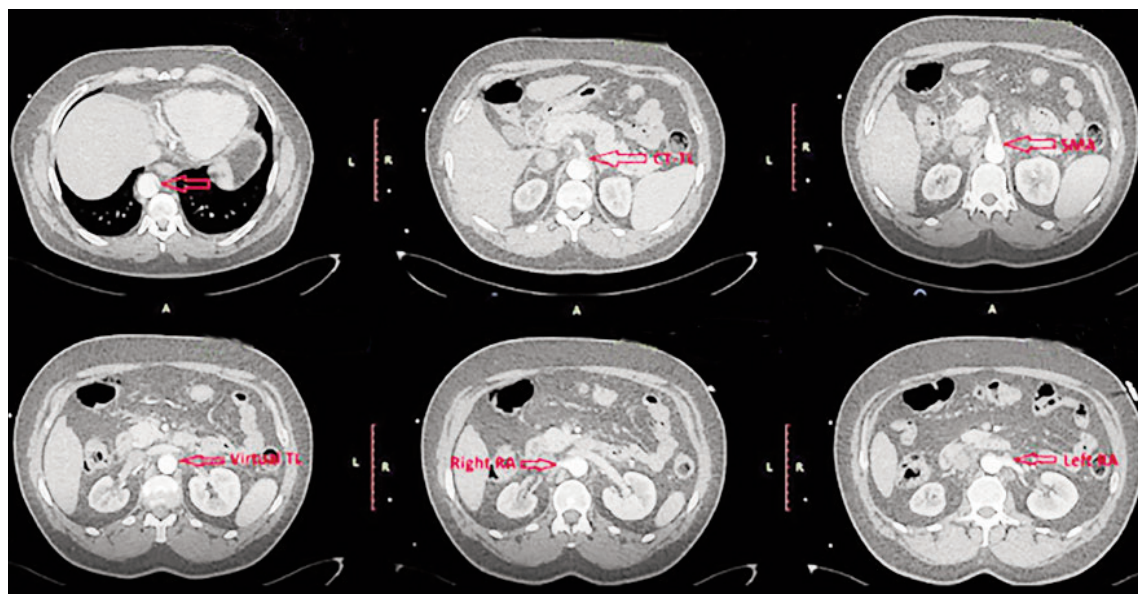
CT angiography images of Type B aortic dissection.
